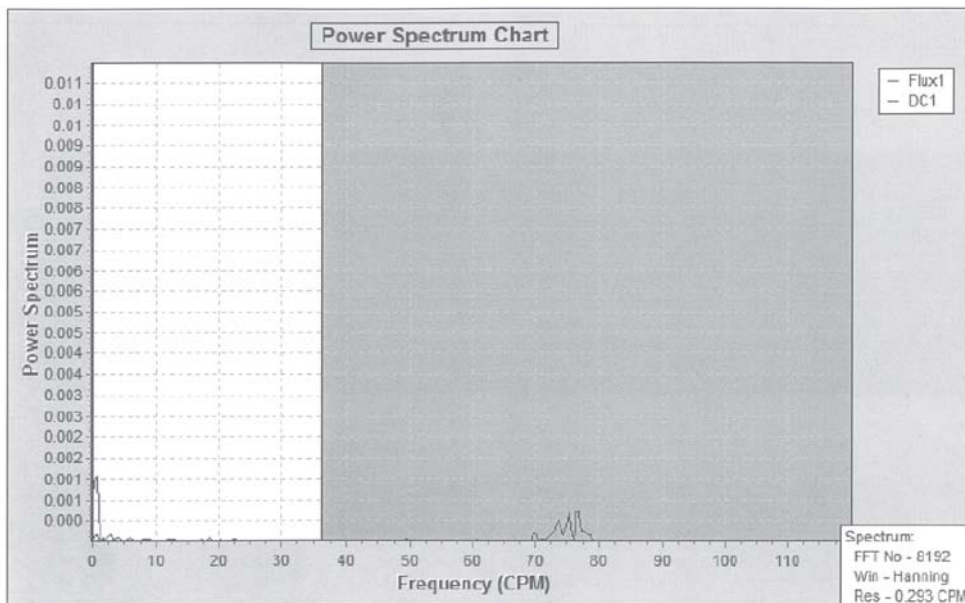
Laser Doppler Power Spectrum Chart examples for a vital tooth 2.1. using: silicon impression combined with light curing periodontal liquid dam
